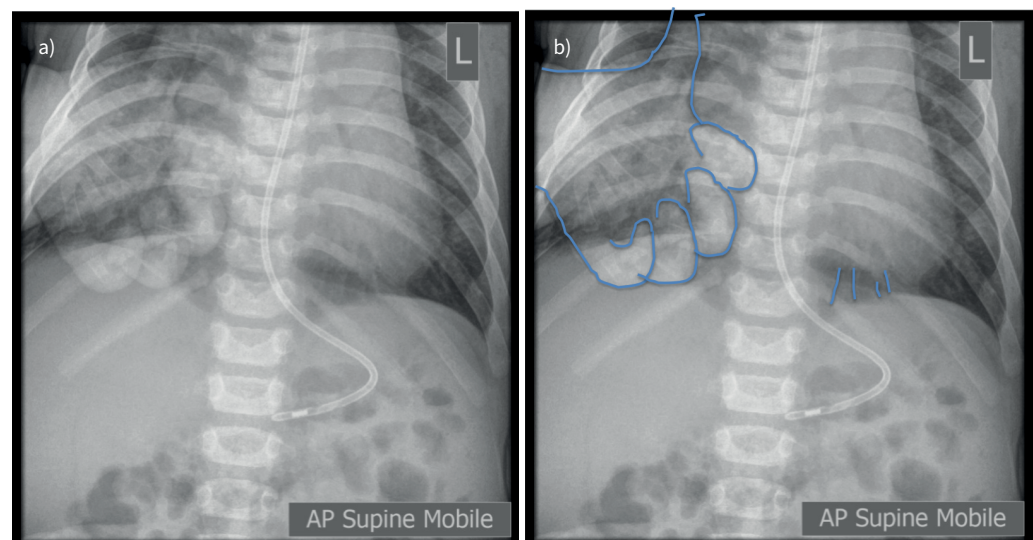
a) Chest radiograph; b) chest radiograph with hand outlined.
